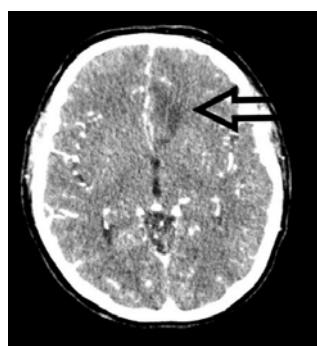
Computed tomography angiography in the axial plane demonstrates a subacute ischemic zone on the frontal parasagittal left (indicated by arrow) as a consequence of cerebral vasospasm.
